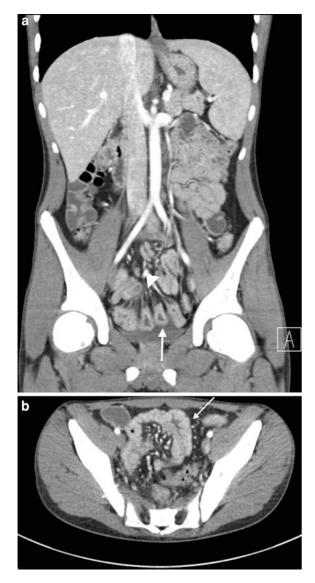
Chron's disease. Coronal (a) and transverse (b) IVenhanced low-dose CT images obtained in a 19-year-old-man with a BMI of 20.5 kg/m² with reduced tube voltage and with AEC (69 effective mAs, 100 kVp; CTDIvol: 2.74 mGy; DLP: 126 mGy cm). Images show mural thickening and enhancement of the terminal ileum (*arrow*) and mesenteric manifestation of Chron's disease (*arrowhead*)
